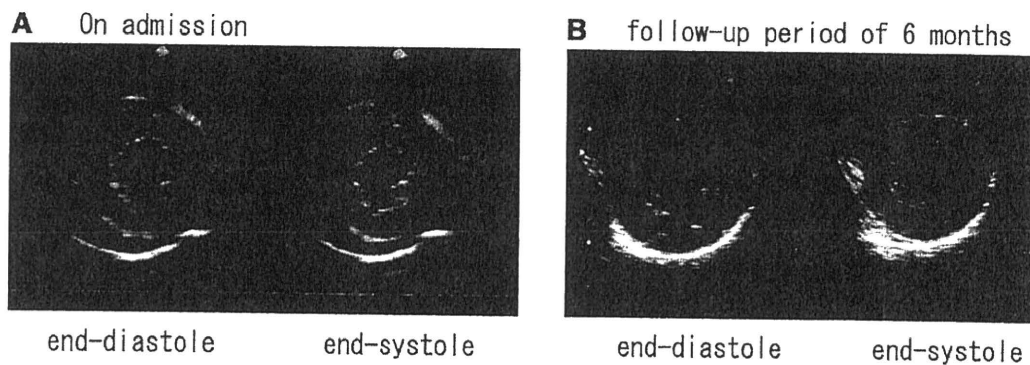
Echocardiography. (A) Large amount of pericardial effusion, wall thickening and severely decreased wall motion. (B) Six months after discharge, all abnormalities have improved dramatically.
